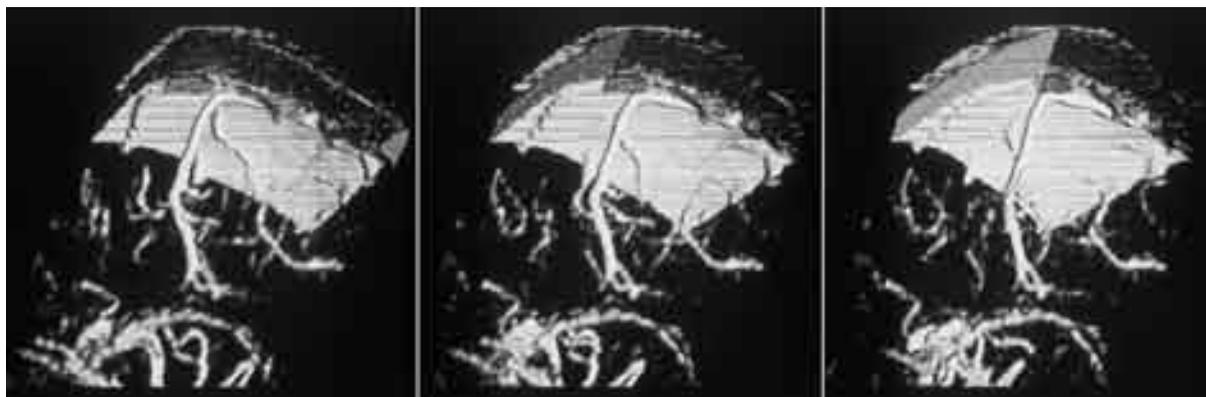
CT venography; A. MPR, B. SSD. C. MIP Vascular malformation in the form of linear vascular structures in the left parietal lobe.
